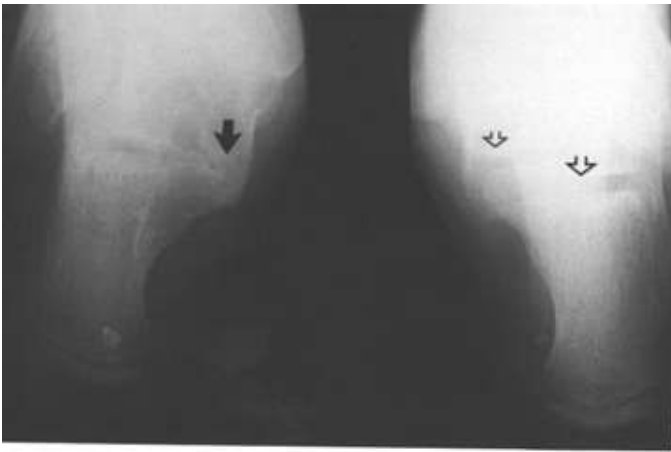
A calcaneal axial radiograph taken of both feet demonstrating the middle and posterior facet as a comparison.
